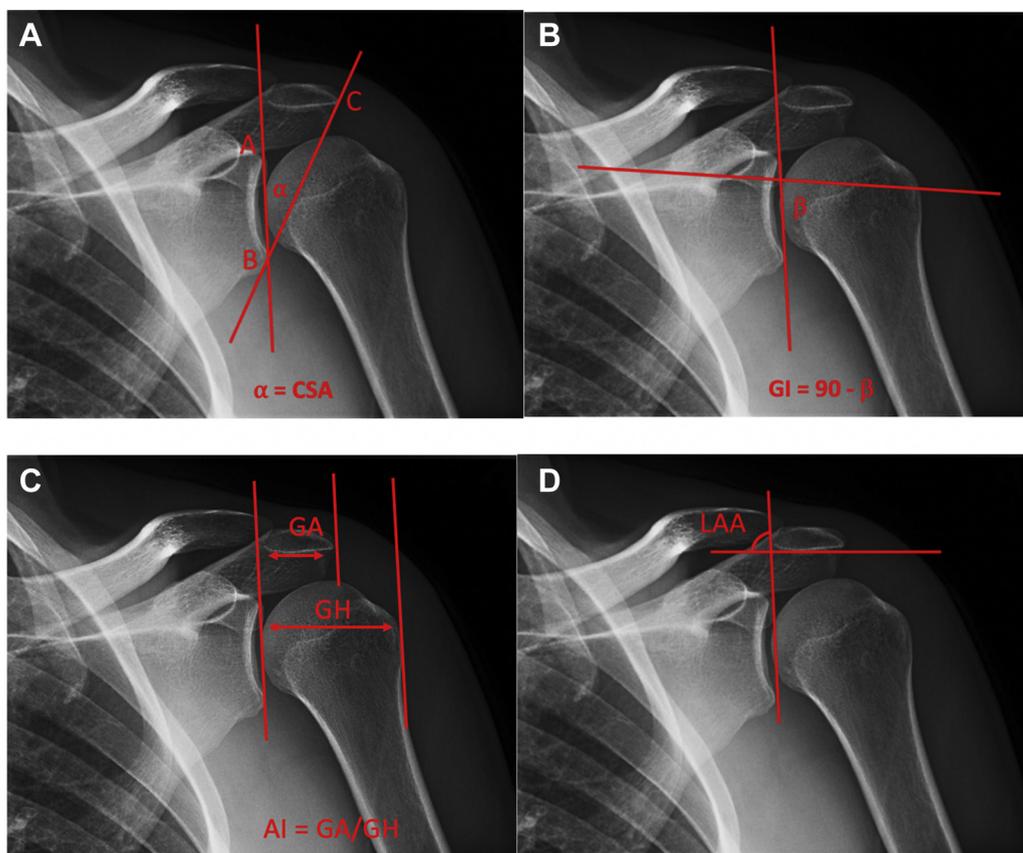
Radiographic measurements of selected anatomic shoulder parameters: critical shoulder angle (CSA) (A), glenoid inclination (GI) (β angle method of Maurer et al²⁸) (B), acromial index (AI) (GA, glenoid-acromial distance; GH, glenoid-humeral distance) (C), and lateral acromial angle (LAA) (D).
